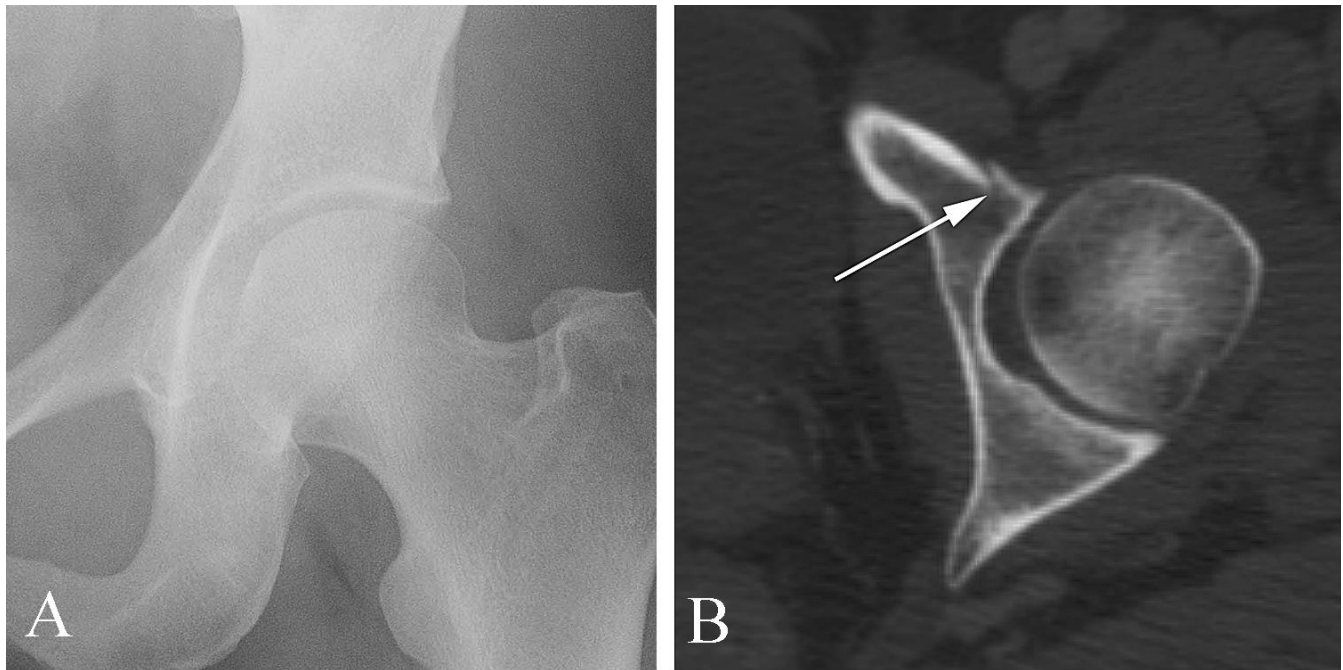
Acetabular fracture not visible on plain film but seen on CT in a 38 year old with pain following trauma. A. AP plain film examination of the hip shows no abnormality. The patient had persistent severe pain and therefore a CT was performed. B. Axial CT of the hip shows a fracture through the anterior column of the acetabulum (arrow).
